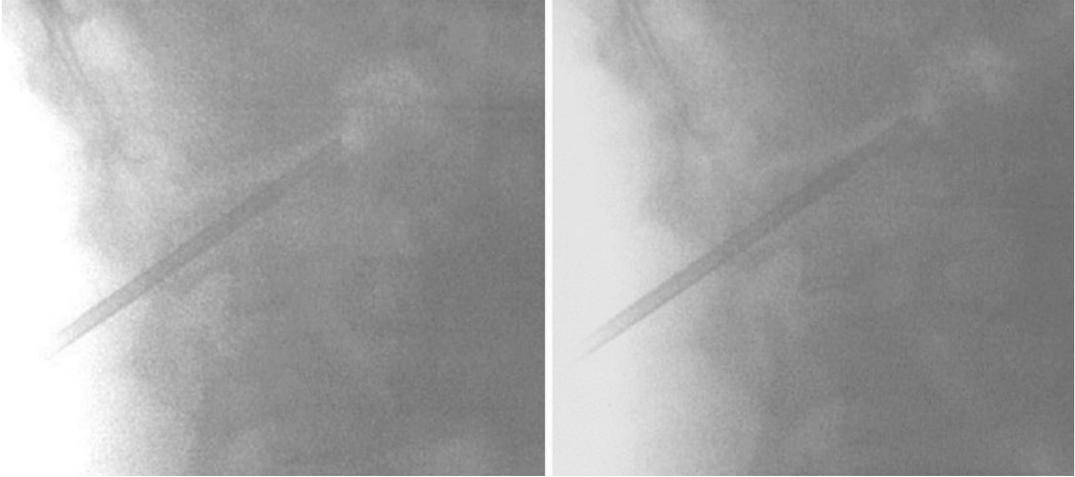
Biopsy disc L2/3 and upper endplate L3, intraoperative x-ray documentation 2 weeks later
